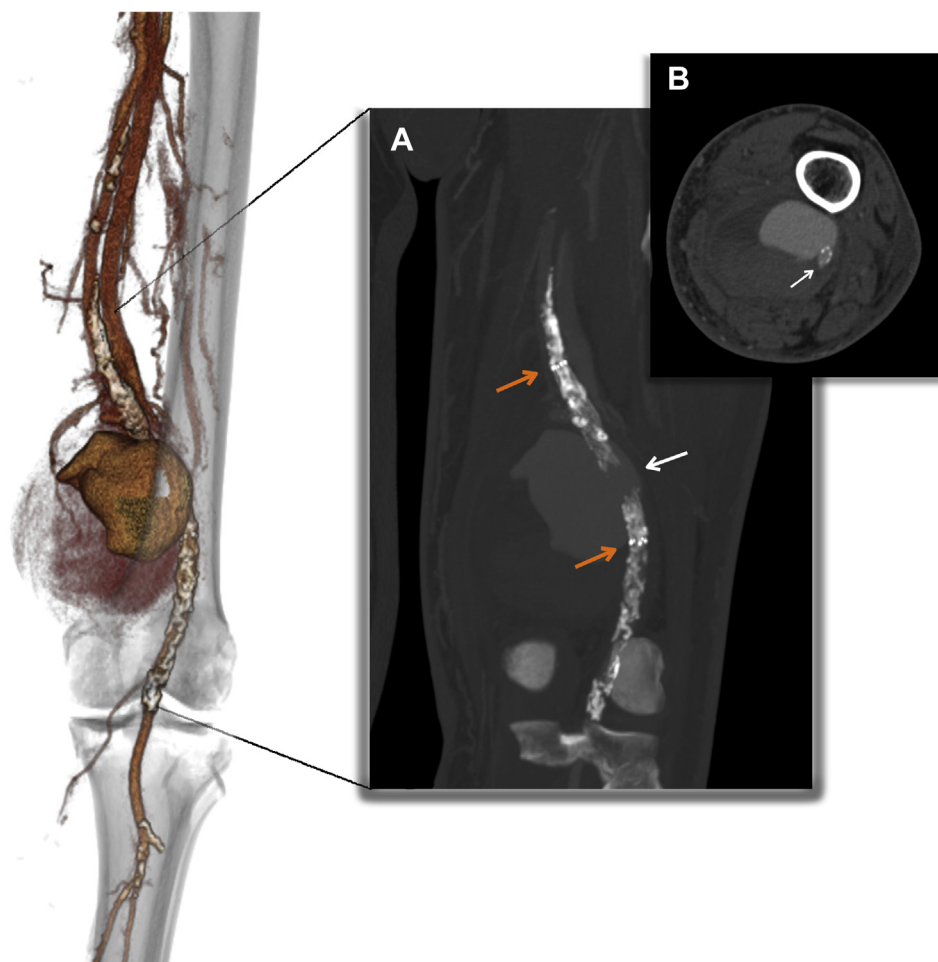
Volume rendering and multiplanar reconstruction (A) of preoperative computed tomography image of the left lower limb showing a stent fracture of the distal superficial femoral artery (SFA; *white arrow*) with a voluminous pseudoaneurysm at the level of Hunter canal (B). Note that the vein below the dilation is completely thrombosed. Proximal and distal stent markers are indicated by *orange arrows*.
